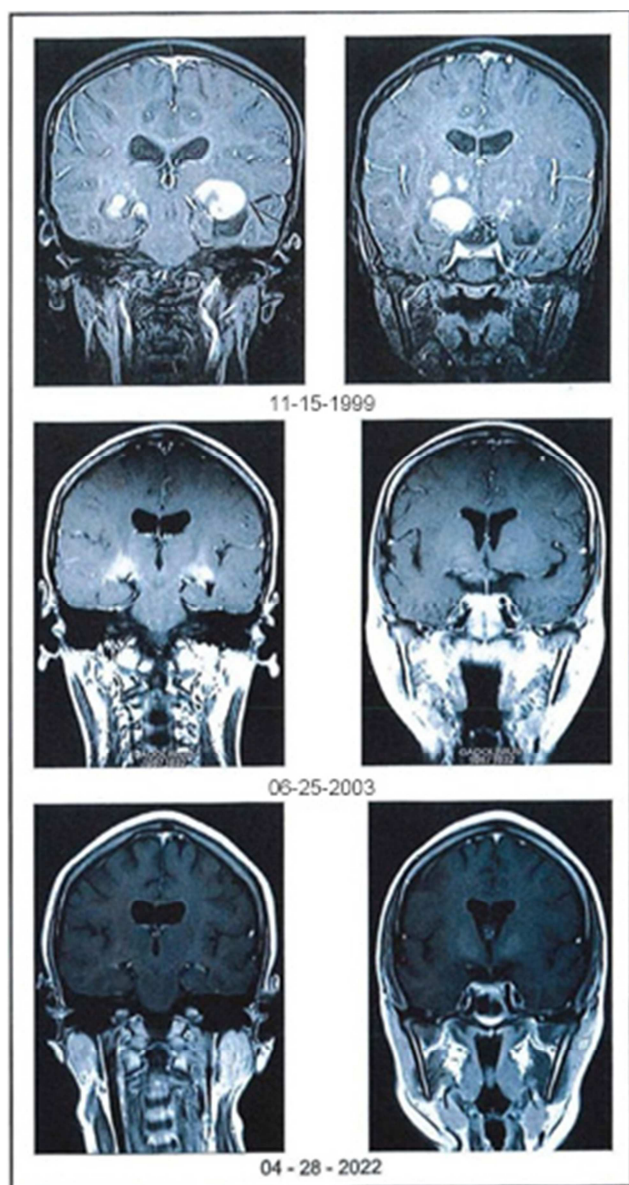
Coronal MRI images of the brain on 11-15-1999 (baseline) showing multicentric pilocytic astrocytoma – three target lesions (> 5mm diameter) were identified, one to the right of midline (see arrow) and two to the left of midline; on 06-25-2003 showing a CR; and on 04-28-2022 showing long-term continuation of the CR. Axial images confirmed these findings. CR=complete response; MRI=magnetic resonance imaging.
